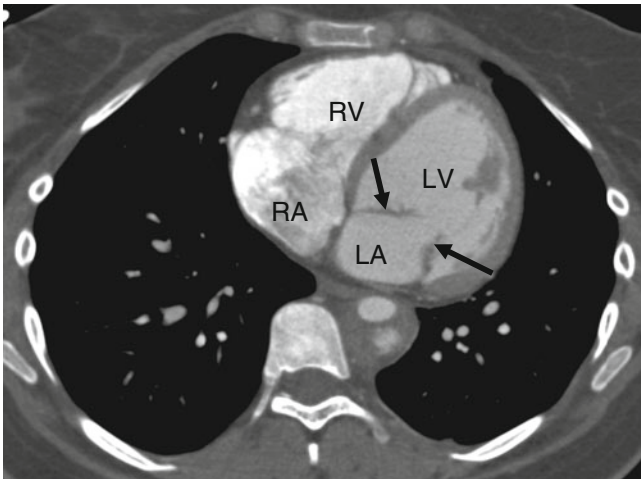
Congenital mitral stenosis. This computed tomographic angiogram shows thickened mitral valve leaflets (*black arrows*). There are a reduced number of chordae. RA right atrium, RV right ventricle, LA left atrium, LV left ventricle
